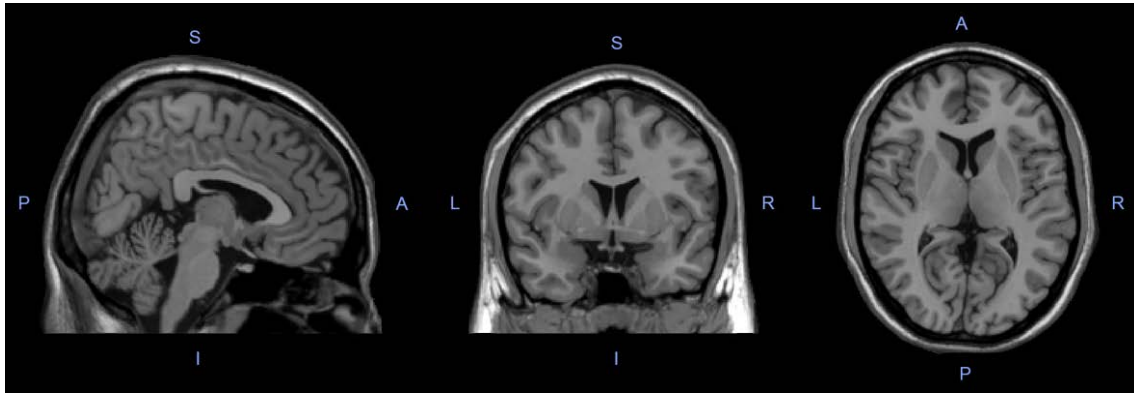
Example of brain acquisition using MRI. From left to right, the slices are sagittal, coronal, and axial. Regions associated with white matter present lighter gray colors. Gray matter areas are generally correspondent with darker gray shades. Finally, cerebrospinal fluid is represented in black. Note: A, P, S, I, L, and R refer to anterior, posterior, superior, inferior, left, and right, respectively.
